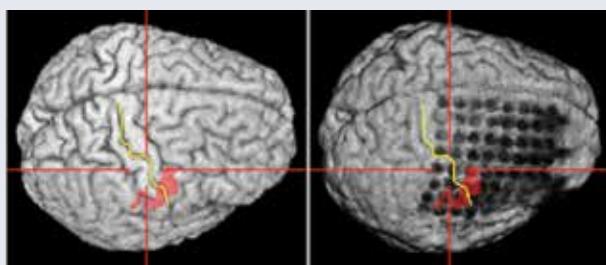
Planning of electrode implantation by calculating the geometry of the electrode grid three-dimensionally and in correct spatial relation to the curvature of the individual brain surface. The electrode positions can also be projected into other MRI data sets, for example with the skull still in place (cf. lower right subfigure). This is helpful for planning the correct approach for craniotomy, i.e. the optimal area for trepanation of the skull.
